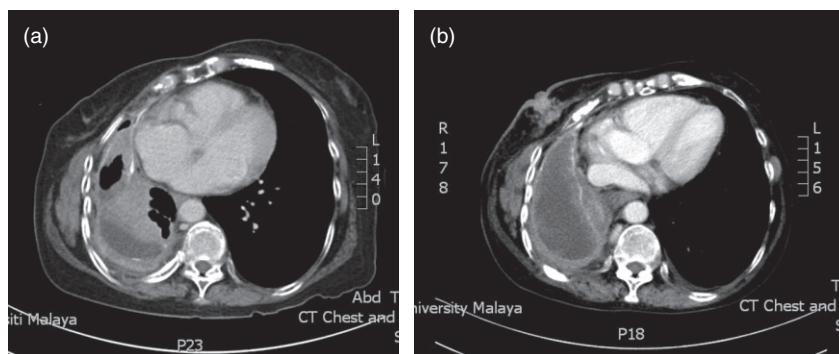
(a) Computed tomography (CT) scan of thorax before the commencement of docetaxel showing reduced right lung volume, tumor in the right lower lobe, right parietal pleural thickening, and a small right pleural effusion. (b) CT scan of thorax showing intact fat planes between the chest wall and breast tissue.
